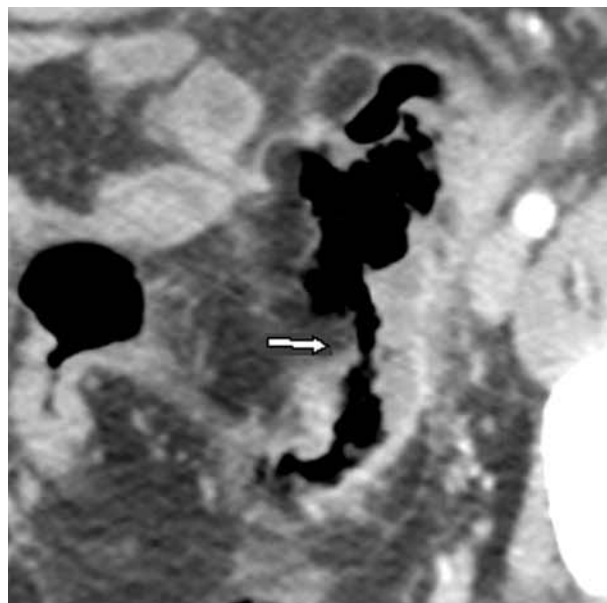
Axial CT views obtained just before laparotomy. The medium sigmoid wall has completely disappeared and colonic gas appears directly contiguous with the mesocolic fat and epiploic appendages. The limits of the completely necrotic segment appear extremely abrupt (white arrow).
